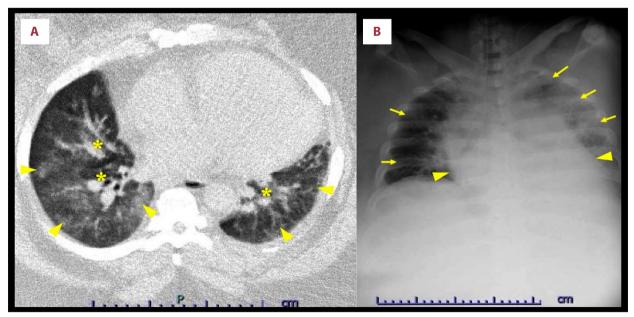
Chest computed tomography (A) and chest X-ray (B) upon admission. (A) Chest computed tomography demonstrating enhanced pulmonary vascular markings (asterisk) and infiltration shadows (triangle arrow) in the bilateral lung fields.
